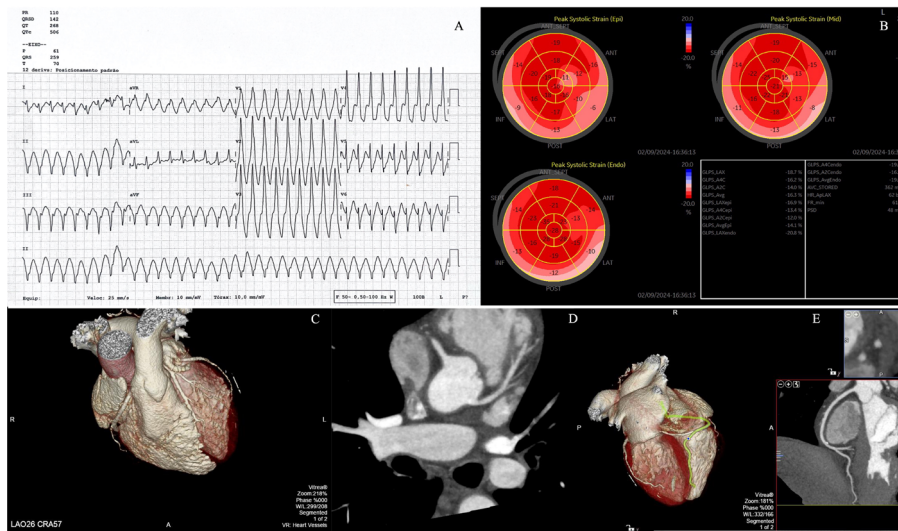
A – wide-complex right bundle branch tachycardia at the emergency department; superior oriented axis; B – Mildly reduced global longitudinal strain. Contrary to coronary artery disease, there is no specific regional longitudinal strain impairment. However, layer specific assessment, namely at the epicardial strain analysis, revealed more evident longitudinal strain affection, which stands for the diagnosis of a non-ischemic cardiomyopathy. C – volume rendering cardiac computed tomography (CT) image; D – CT axial views of the coronary arteries; E – curved planar reconstruction of the right coronary artery. There was non-obstructive coronary artery disease.
